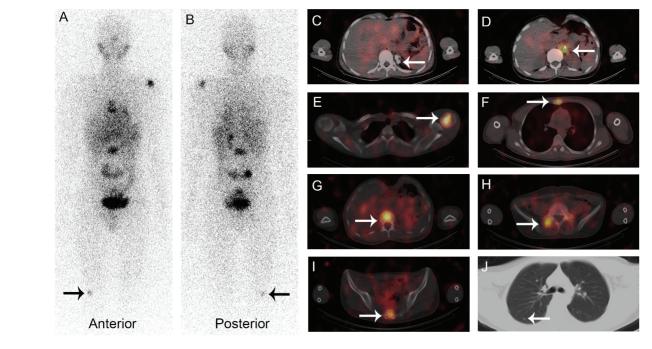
Planar (A and B) and SPECT/CT (C-J) views of [1311], C); MIBG avidity, D); MIBG scan, show an [1311] MIBG-avid lesion in the paraaortic region, E); as well as multiple [1311], F); MIBG-avid bone metastases in the left humeral head, sternum, G); T₁₂, H); L₅, I); sacrum, and distal right femur (black arrow). The calcified tumoral lesion in the left adrenal gland shows no [1311] J); MIBG avidity, indicating a response to prior treatments. Also, a subcentimetric pulmonary nodule in the left lower lobe demonstrates no uptake
